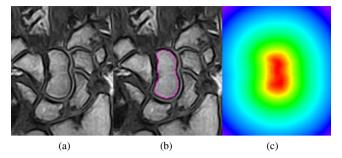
Distance map of the registered capitate. In (a) the coronal slice of the original MRI volume, in (b) the segmentation of the capitate overlaid on the grayscale image and in (c) the registered distance map.
